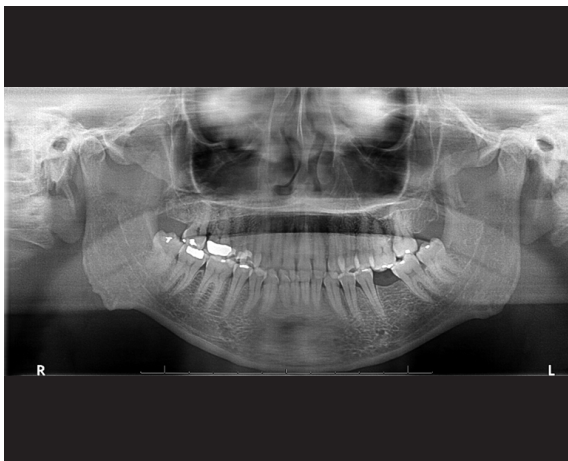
Panoramic radiograph as part of the pretreatment records.
